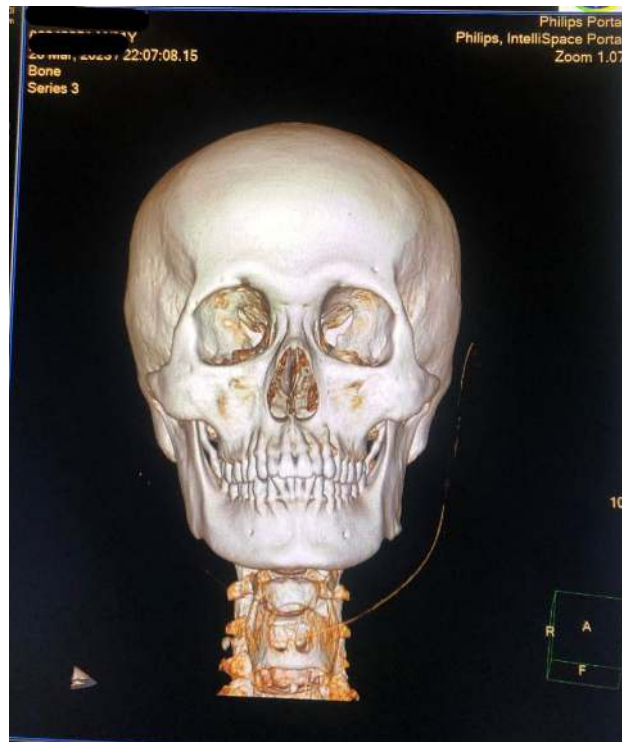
CT Scan Image of the 3D AP
